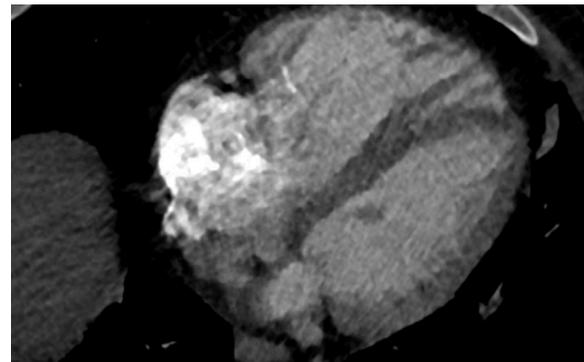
Coronary CT showing a dilated right ventricle
